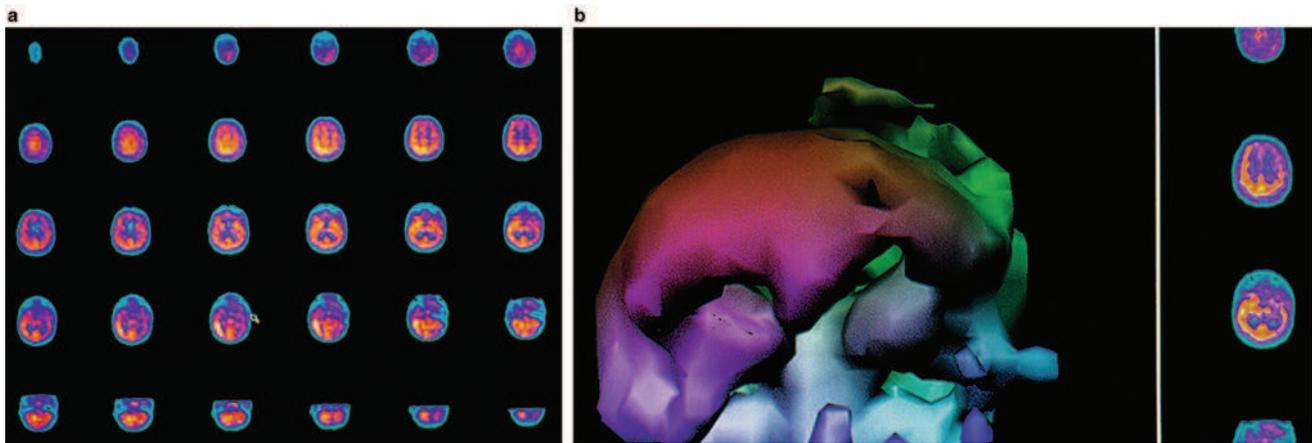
(a) HMPAO SPECT brain imaging, transverse slices, 1 month postinjury. Note severe reduction in left frontal, parietal, and temporal brain blood flow with luxury perfusion in the right occipital
